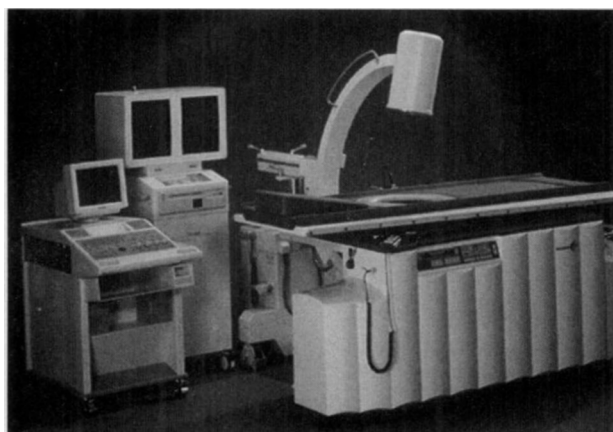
Piezolith 2500 piezoelectric lithotripter (R. Wolf Company, Knittlingen, Germany) with integrated ultrasonography for locating stones during therapy. Shock waves originate from piezoelectric elements at bottom of water-filled basin. Self-focusing elliptic device with integrated ultrasound scanner leads shock wave through water and latex membrane directly into focus zone of 5×15 mm.
